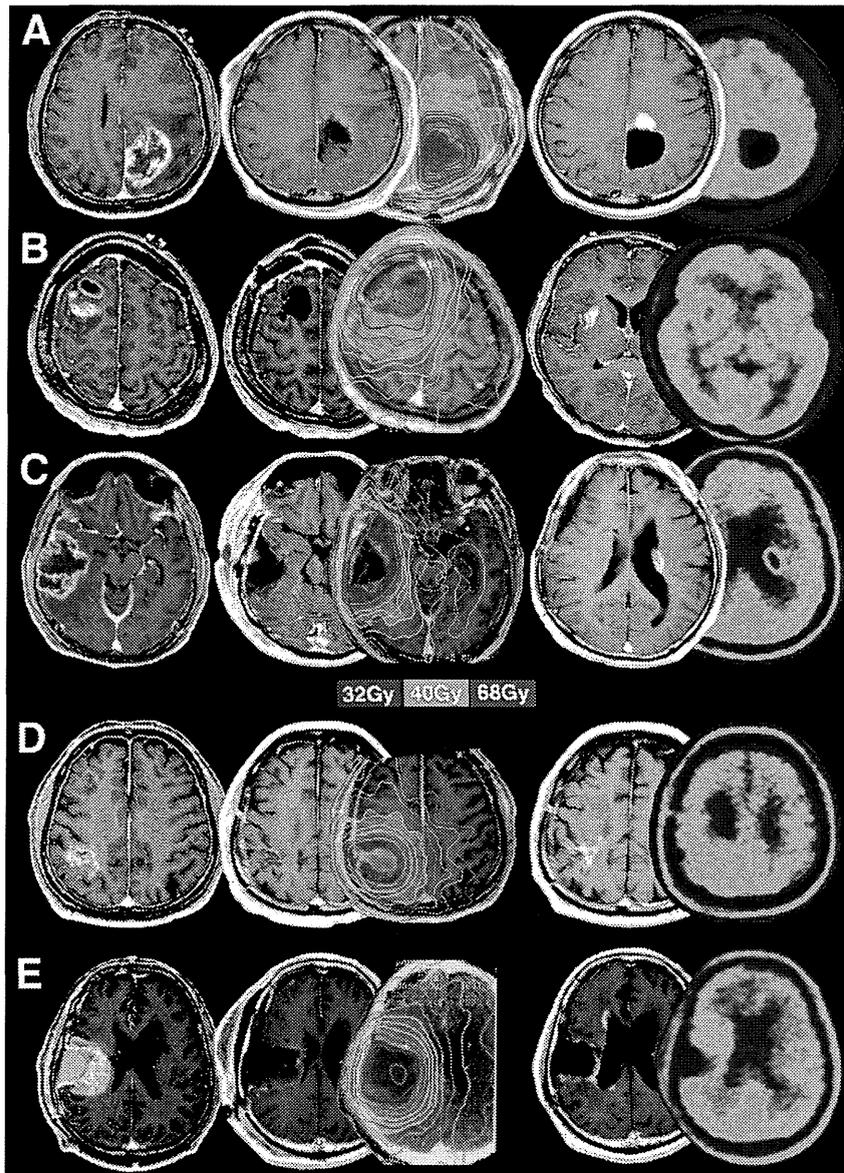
Failure patterns and radiation necrosis patterns. Three different patterns of failure were evident: local (A), distant (B), and disseminated (C). Two different patterns of radiation necrosis were evident: regional necrosis (D) and necrosis in the subventricular zone (E). Enhanced magnetic resonance imaging (MRI) performed before (left) and after (middle) surgery and at the reappearance of enhanced lesions on MRI was demonstrated with isodose maps and methionine-positron emission tomography.
